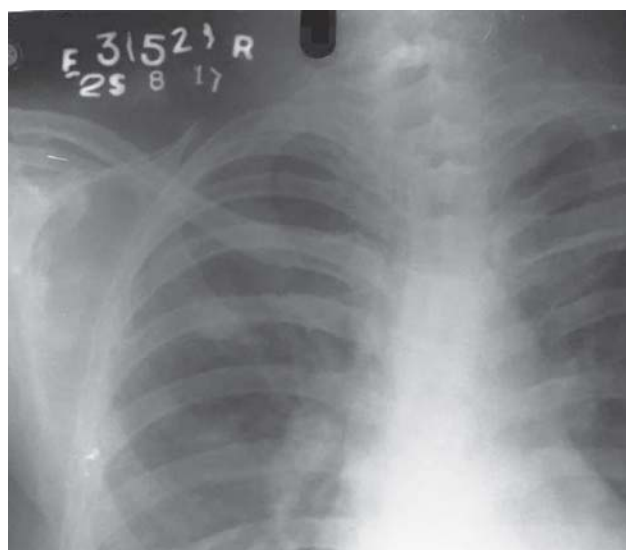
Chest radiograph (postero-anterior view) showing bilateral nodular opacities.
